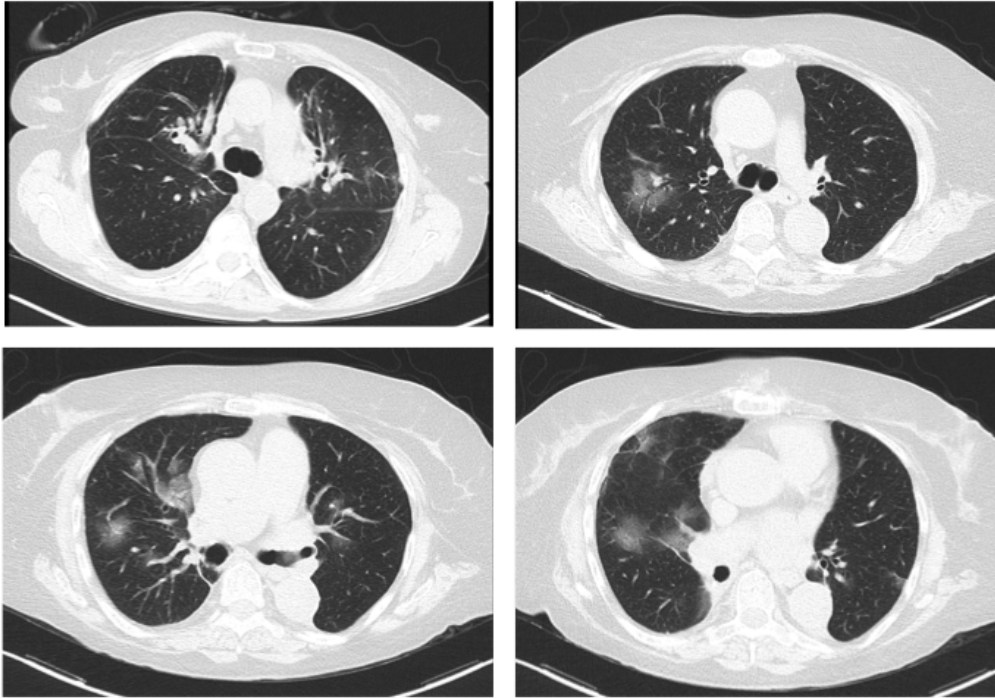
CT scan from patient 3 on admission
